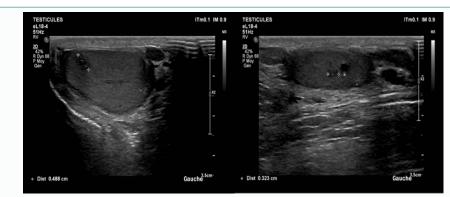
Testicular ultrasound showed three hypoechoic nodules in the left testis.
